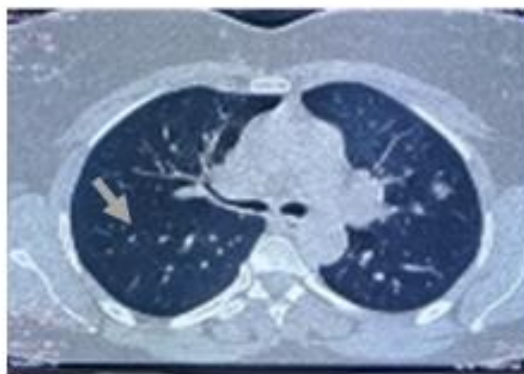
Chest CT revealed Nodular Fireplaces Surrounded by Frosted Glass.
